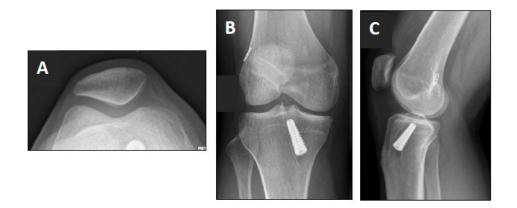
Radiographic assessment of the tibiofemoral and patellofemoral compartments. A: posterior-anterior view; B: lateral view; C: skyline view.
